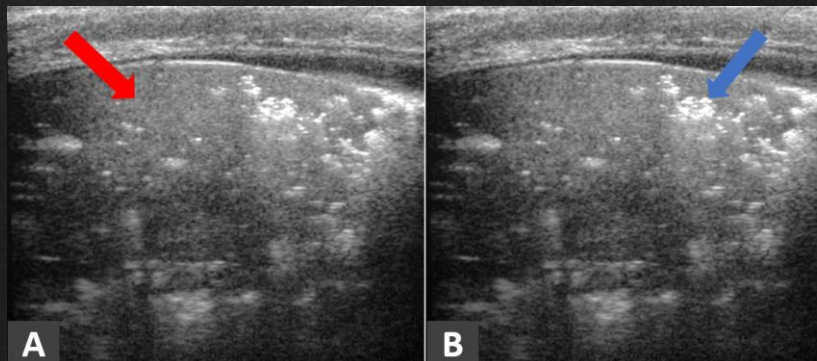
39-year-old woman presents with dyspnea and fever four days ago. Lung ultrasound demonstrates a pulmonary hepatization (A) - (red arrow), used to describe pulmonary consolidation with echogenic points representative of air bronchogram (B) - (blue arrow).
